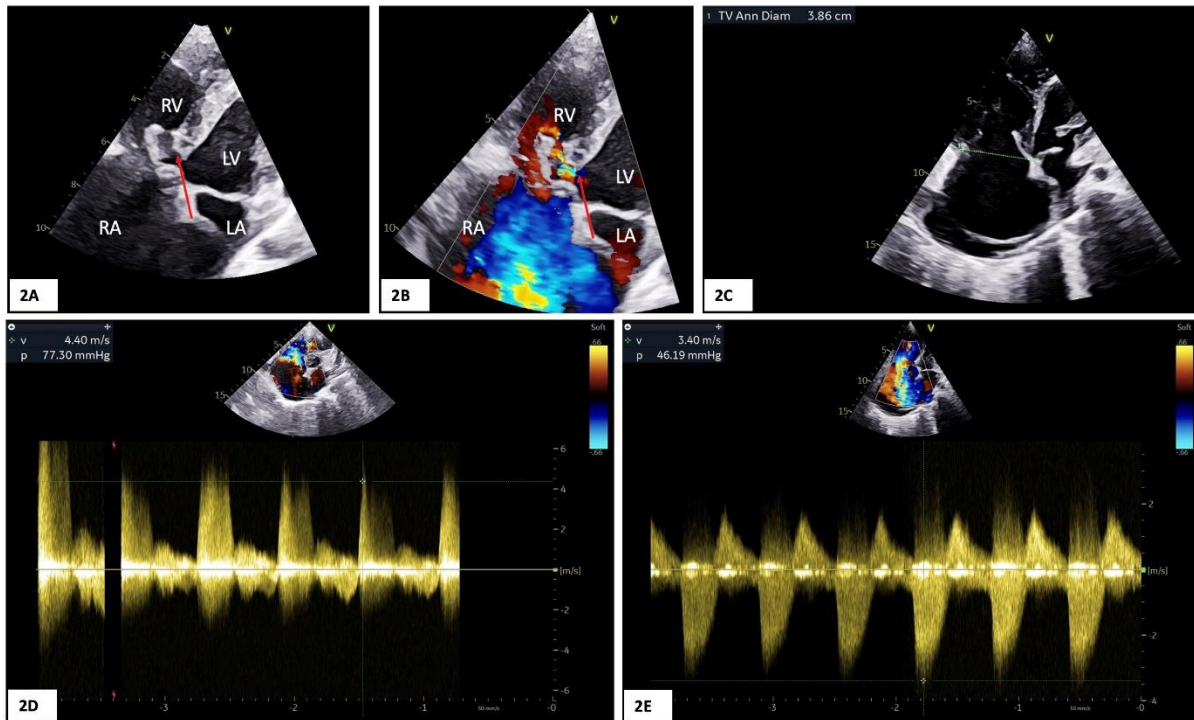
Two-dimensional echocardiography. 2A, 2B: Apical four chamber view without and with color flow image demonstrating ventricular septal defect indicated by red arrow. 2C: Apical four chamber view showing tricuspid annular diameter of 3.86cm and moderate pericardial effusion behind right atrium. 2D: Continuous wave doppler across the ventricular septal defect showing pressure gradient of 77mm Hg. 2E: Continuous wave doppler across the tricuspid regurgitation showing pressure gradient of 46mm Hg.
